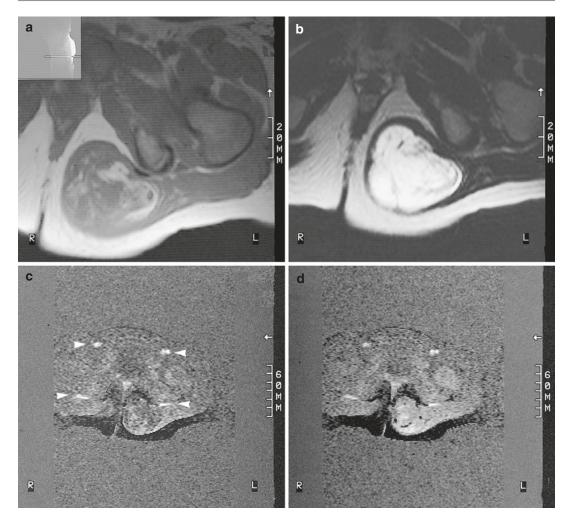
(a–d) Tissue characterization with dynamic MRI. A 5-year-old boy with painful swelling of the buttocks. (a) The axial spin-echo T1-weighted image shows a poorly defined mass in the left gluteus maximus muscle. The tumor is heterogeneous, with both ill-defined areas of intermediate signal intensity and areas of high signal intensity corresponding to fat. (b) On the turbo spin-echo T2-weighted image, the mass is well defined and predominantly of very high signal intensity corresponding to fat. to fatty tissue. (c) Early dynamic, gadolinium-enhanced
